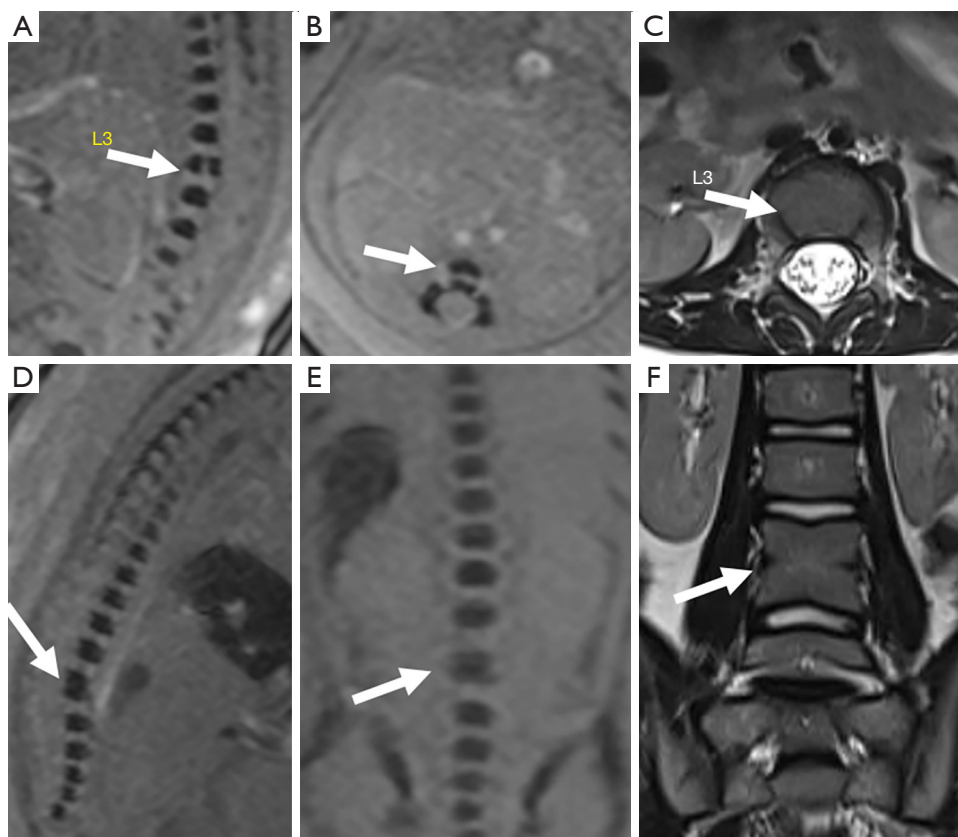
Fetuses with vertebral anomalies. (A-C) Case 72, L3 coronal vertebral cleft at 25 weeks +6 d, demonstrated as a hyperintensity cleft band in sagittal (A, arrow) and axial (B, arrow) SWI images. Postnatal axial T2WI (C, arrow) showed cleft disappear at 7 months; (D-E) Case 90, L3-4 block vertebra at 25 weeks +3 d in sagittal (D, arrow) and coronal (E, arrow) SWI images, corresponding to postnatal coronal T2WI finding (F, arrow) at 10 months. SWI, susceptibility-weighted imaging; T2WI, T2-weighted imaging.
